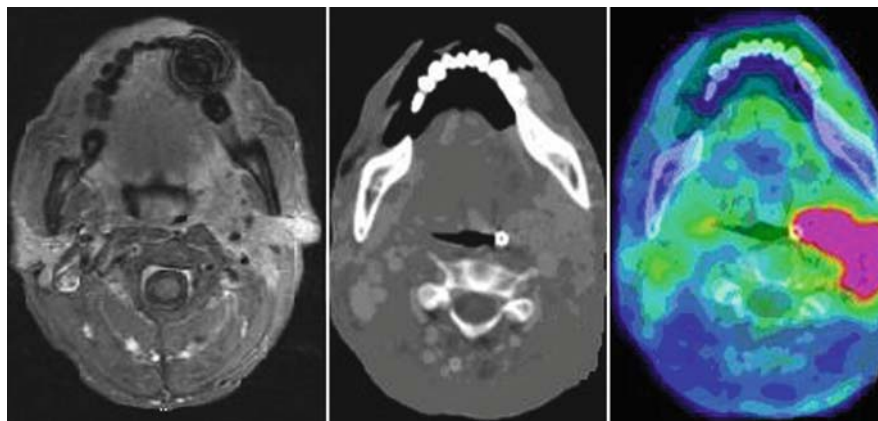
An example of a treatment planning PET-CT scan with contrast in a patient with a T4aN2bM0 left tonsillar squamous cell carcinoma. The figure shows an axial slice across the tumor on a T1-weighted MRI scan with gadolinium, CT scan with contrast and merged PET-CT
